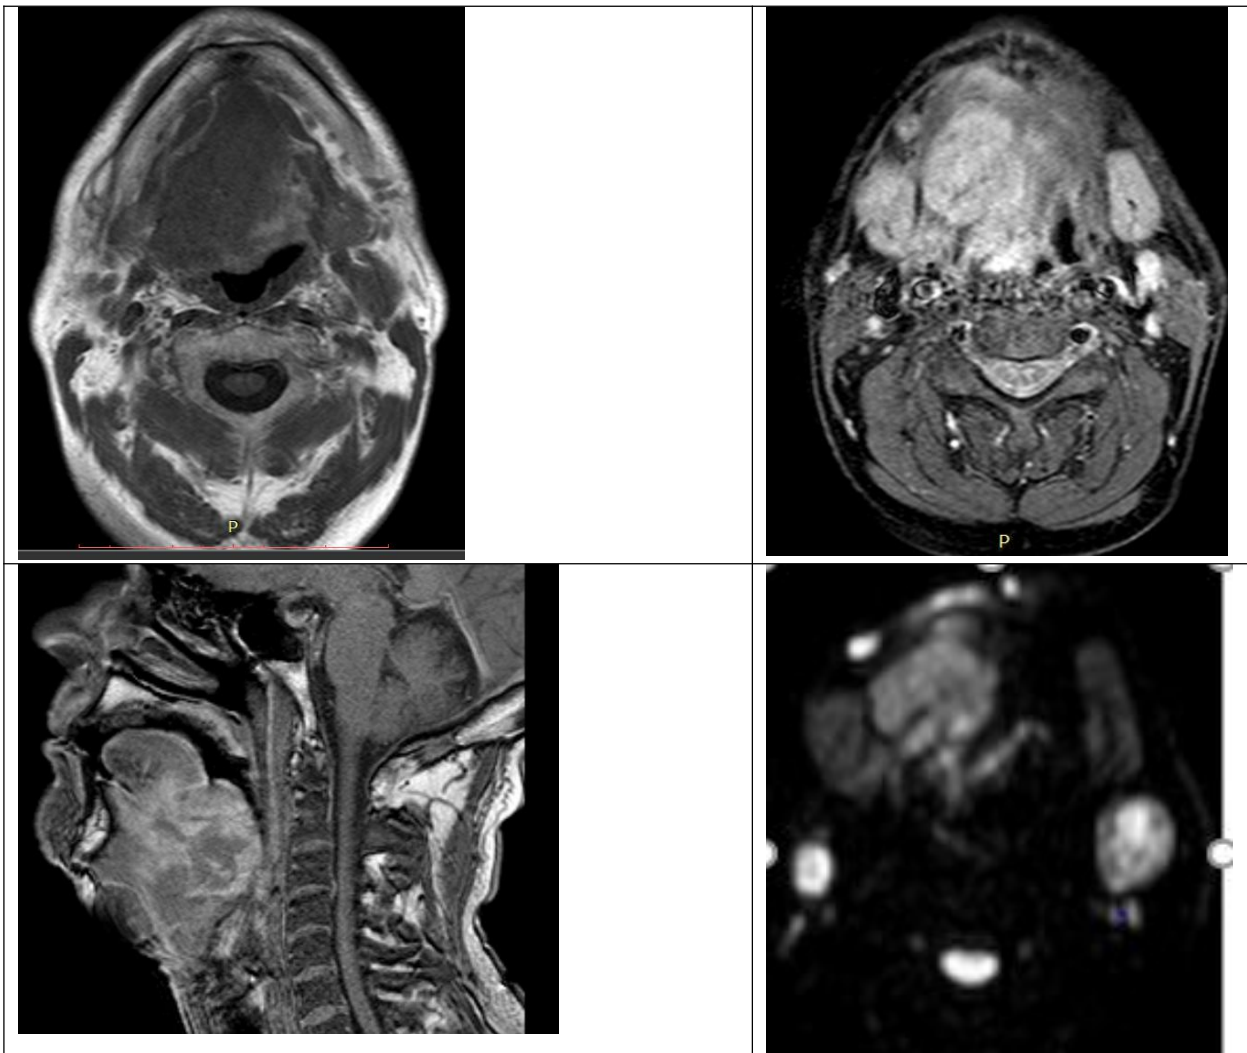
40-year-old male patient with painless swelling in the upper right palatal region ago MRI examination demonstrated a large ovoid soft tissue mass with clear margins originating from the posterior soft palate A) Axial T2WI shows that the mass has heterogeneous signal intensity. B) Axial STIR image
